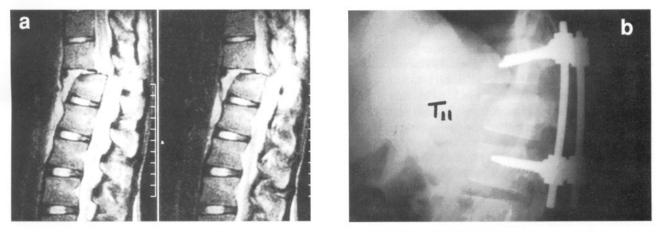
A fracture dislocation at T10-T11, with destruction of the T11 vertebral body, (a) Magnetic resonance imaging shows the obliteration of the spinal canal, (b) A postoperative lateral film shows the fracture reduced and stabilized with posterior instrumentation using pedicular screws.
